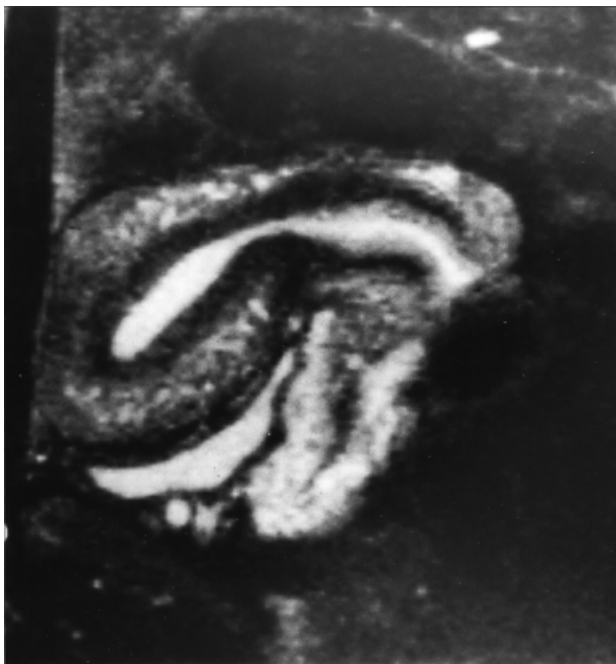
Magnetic resonance imaging of the sagittal section of the anteverted uterus of a fertile woman without endometriosis. The layers of the uterine wall can clearly be distinguished from each other. From inside to outside on the level of the uterine cavity: the endometrium with high signal intensity; the stratum subvasculare of the myometrium with low signal intensity ('junctional zone'), the stratum vasculare of the myometrium with high but more irregular signal intensity and the stratum supravasculare of the myometrium with intermediate signal intensity. The halo comprises about one-quarter of the thickness of the whole myometrium on the level of the uterine corpus.
